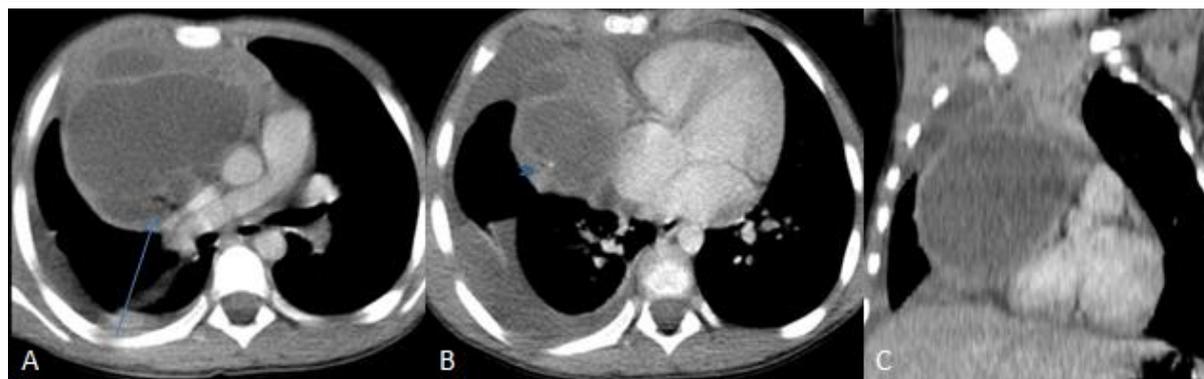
Thoracic CT scan with injection of iodinated contrast (A and B axial, C: coronal) shows a large anterior mediastinal tumor lateralized to the right, well circumscribed, cystic, septate with heterogeneous content, with fatty areas (arrow), and intra-tumoral calcifications in places (arrowhead). It pushes back the mediastinal elements towards the contralateral side without any detectable invasion, and is associated with the presence of a reactive homolateral encysted pleurisy
